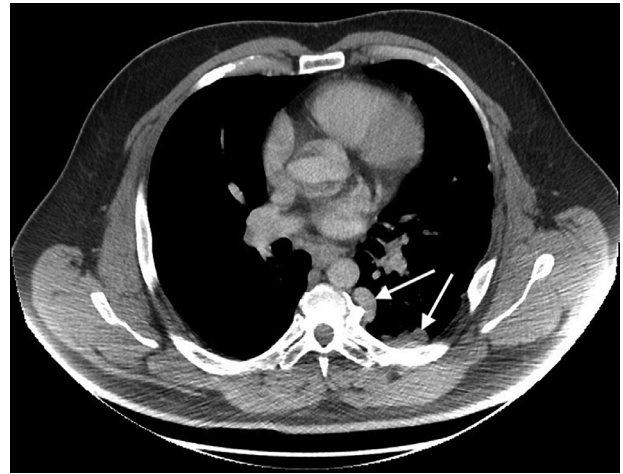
CT enhanced image, axial projection, displaying nodularity (arrows) of left pleural space. CT, computed tomography.
